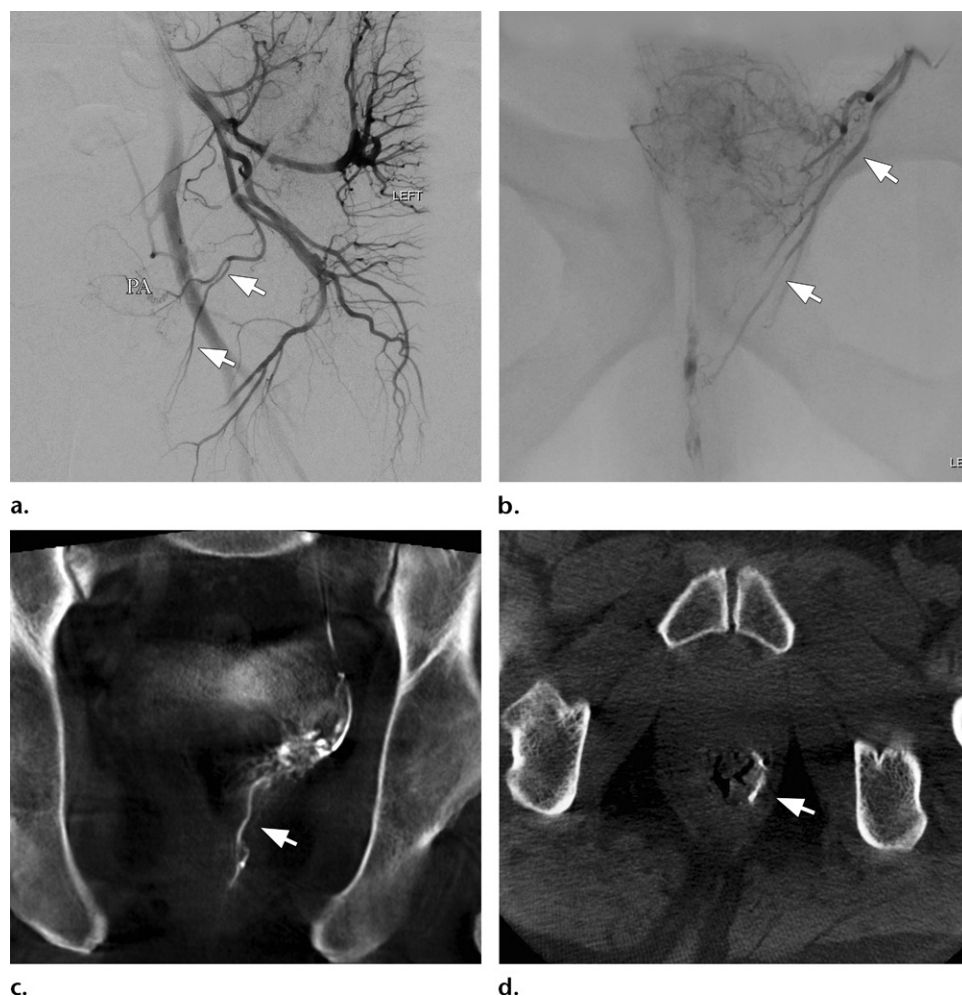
Middle rectal artery arising from the PA. (a) Arteriogram shows the middle rectal artery (arrows). Note the characteristic craniocaudal course. (b) Selective PA arteriogram shows the middle rectal artery (arrows) and rectal blush. (c) Coronal cone-beam CT image shows the craniocaudal course of the middle rectal artery (arrow). (d) Axial cone-beam CT image shows perfusion to the rectal wall (arrow). In this case, the microcatheter was advanced distal to the middle rectal artery origin, and embolization was performed safely.
